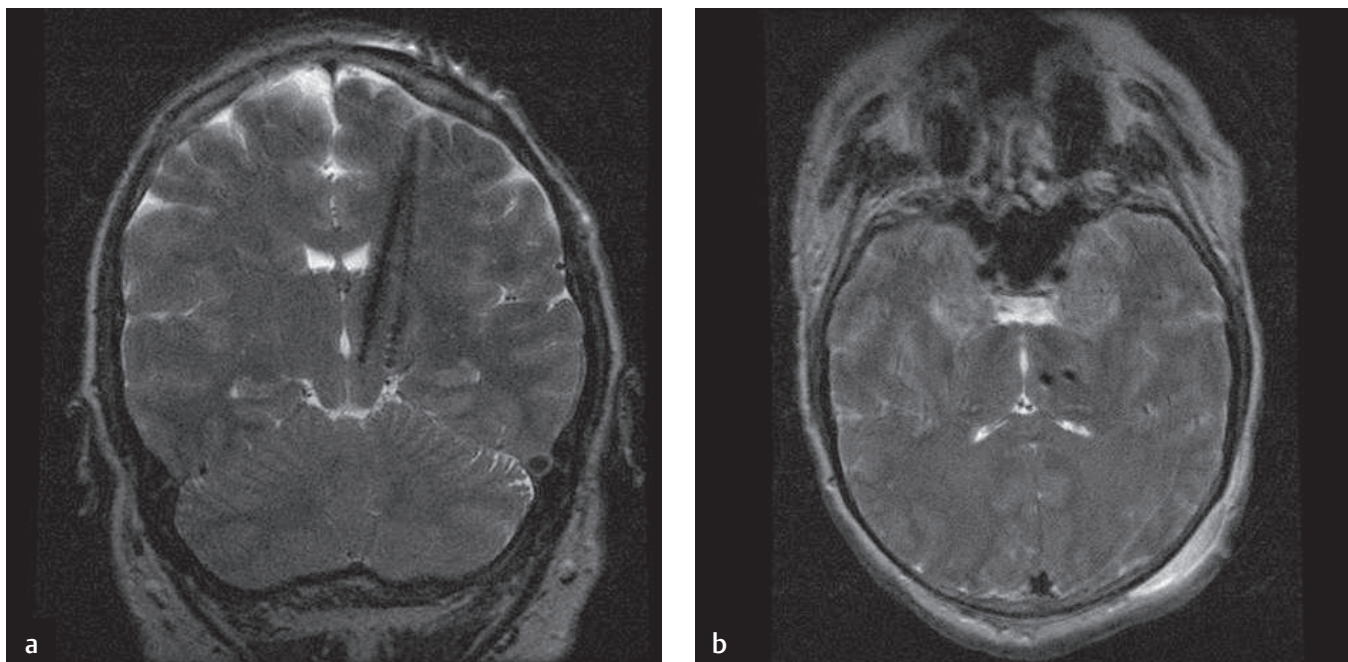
(a, b) Thalamic and PVG (periventricular gray) DBS (deep brain stimulation). Axial T1-weighted MRI (magnetic resonance imaging) section demonstrating the location of thalamic sensory and PVG electrodes in a patient with chronic refractory facial neuropathic pain.
